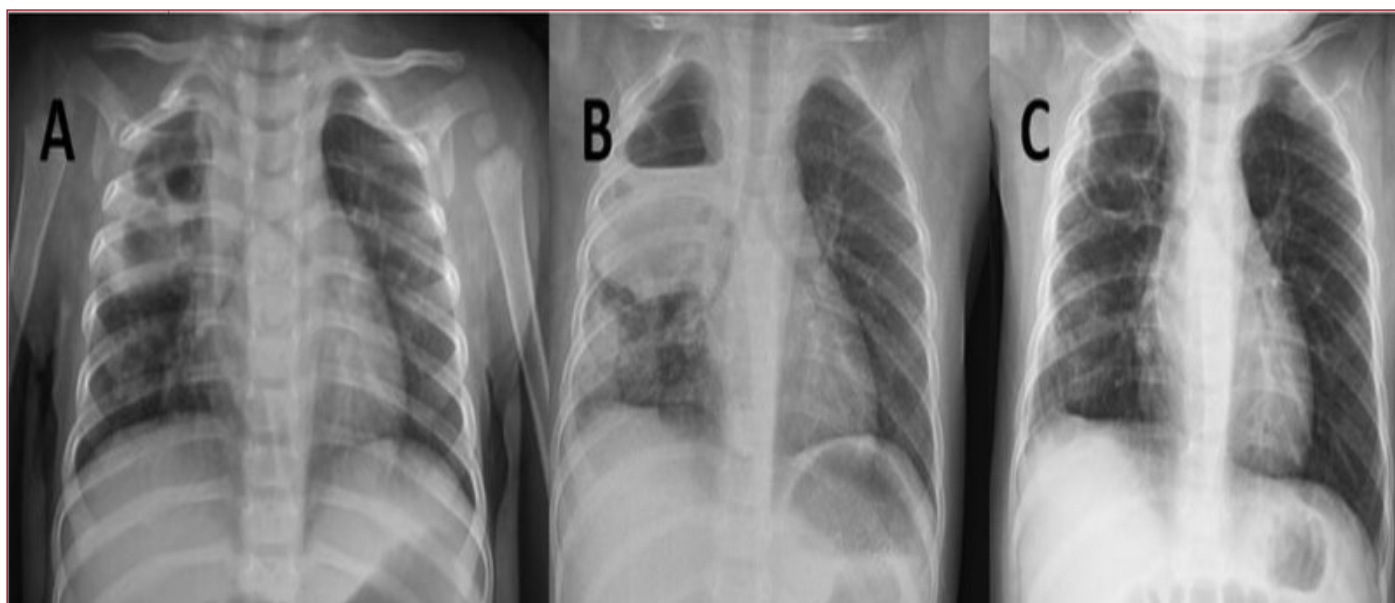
Chest X-ray of patient (A: At admission, B: The 6th day of treatment, C: The 30th day of treatment)
